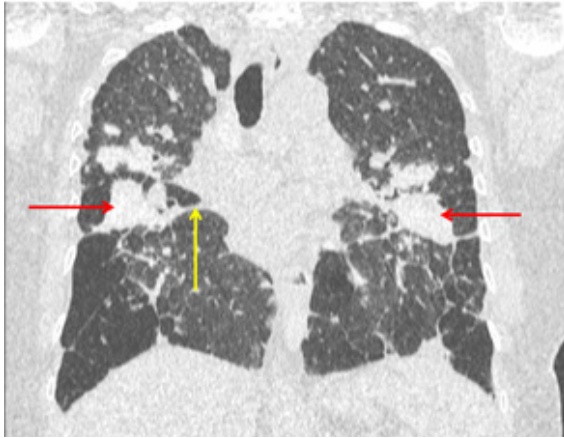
HRCT thorax axial view shows hyper-inflated lungs with multiple calcified mass (conglomerate mass indicated by red arrows) in both perihilar regions with surrounding fibrosis and adjacent pleural thickening (indicated by the yellow arrow)
